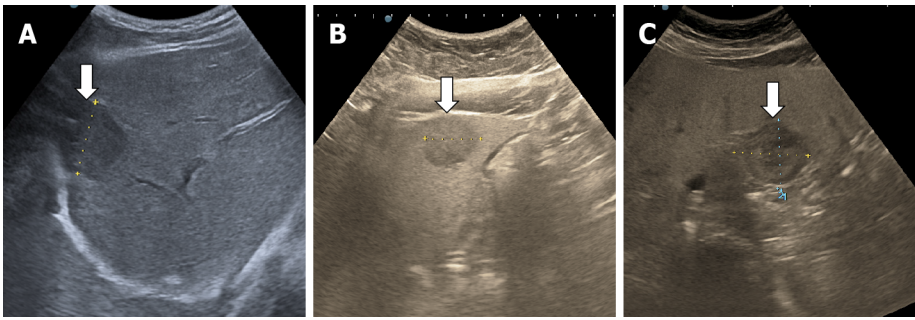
Examples of hypoechoic hemangioma relative to a hyperechoic, fatty liver. A and B: B mode ultrasound show a hypoechoic lesion with a subdiaphragmatic (A) and subcapsular position (B); C: Case of hepatic hemangioma in fatty liver with an area surrounding the lesion appears hypoechoic and resembles a halo, an appearance termed a "pseudohalo".
